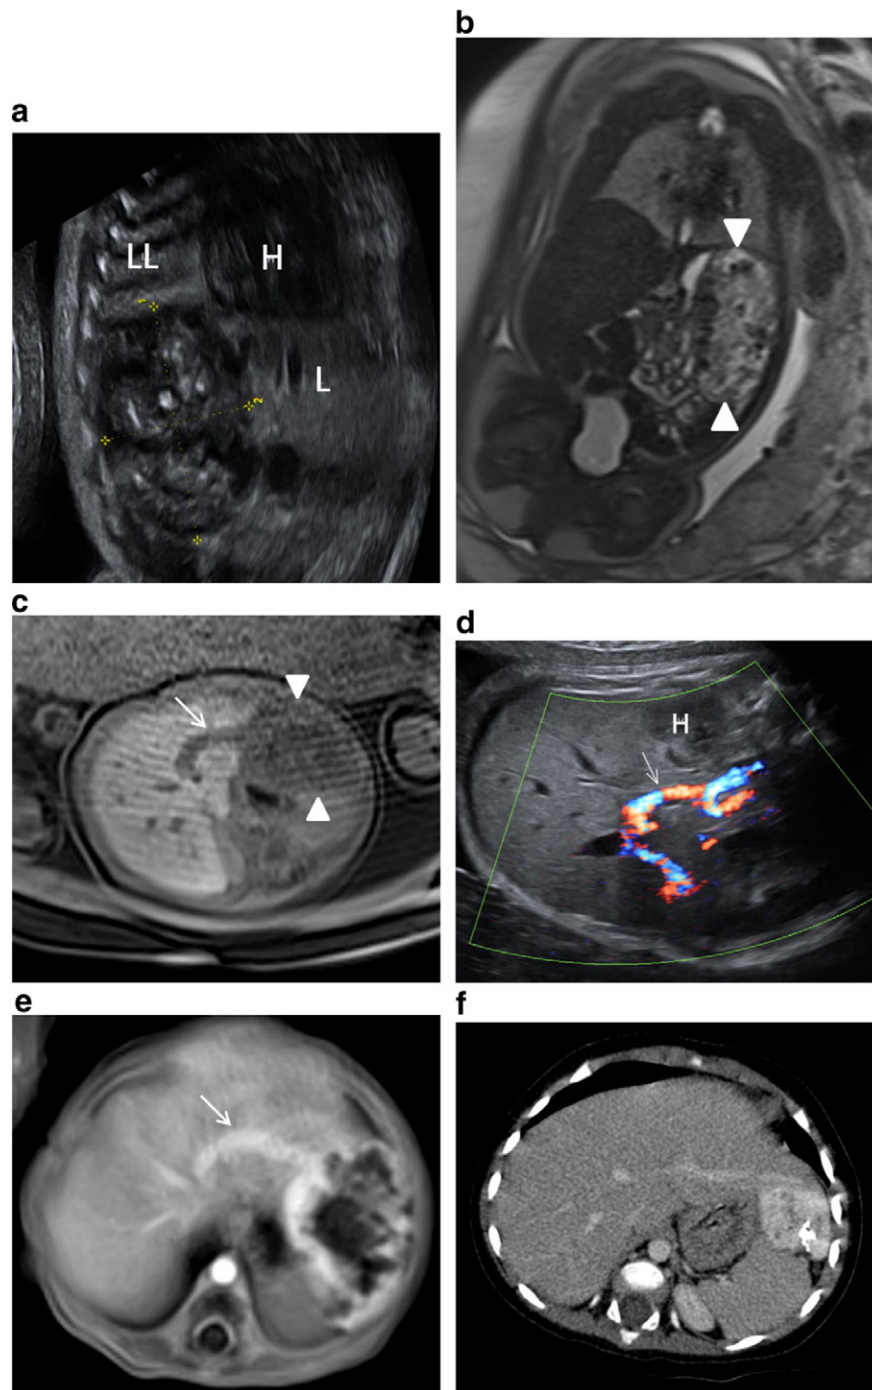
(Case1, female fetus).— The left sagittal (a) US image performed at the 33rd gestation week (GW) shows a voluminous, solid and heterogeneous left hepatic mass (LL: left lung; H: heart; L: liver). Yellow marks are placed at the borders of the lesion. Coronal (b) T2-W fetal MR image at the 33rd GW shows the inhomogeneous tumor, arising from the lateral edge of the left hepatic lobe. Note the numerous tubular forming flow voids vascular structures. Axial T1 W (c) at the 33rd GW and transverse US abdominal images at the 35th GW (d) clearly evidence the extremely enlarged left hepatic vein (white arrows). Note that the images have been turned in order to improve the recognition of the fetal organs. Postnatal T1-W MR image after iv administration of contrast at day 4 (e) shows the marked early peripheral enhancement of the lesion in the arterial phase and confirms the enlarged left hepatic vein as the venous drainage of the lesion (white arrow). Contrast-enhanced abdominal computed tomography shows the development of calcifications and the significant regression of the tumor at the age of 18 months (f).
